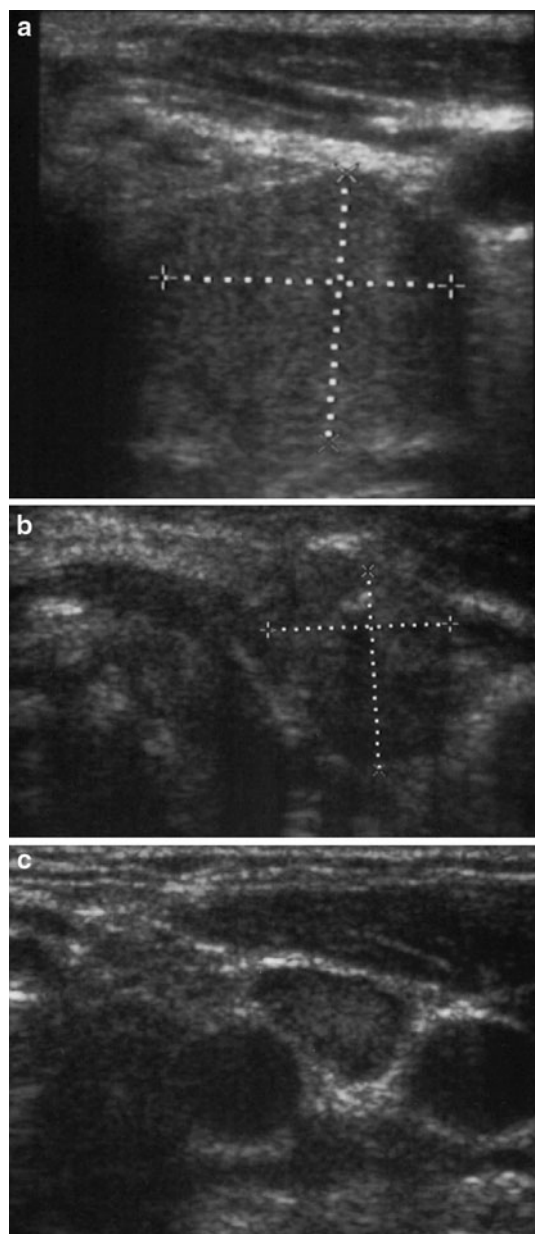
Examples of neck ultrasound images of residual tissue (a, b) in the thyroid bed after surgery, and of lymph node metastasis (c). a Residual tissue between trachea and carotid. b Residual tissue with calcification between trachea and carotid. c Lymph node metastasis between carotid and jugular vein
